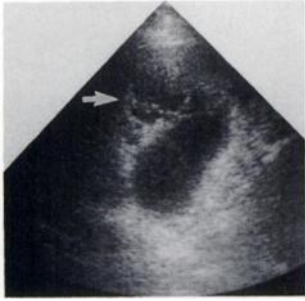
Gallbladder ultrasonogram, longitudinal view: septated, pericholecystic fluid collection (arrow) compatible with localized perforation.
